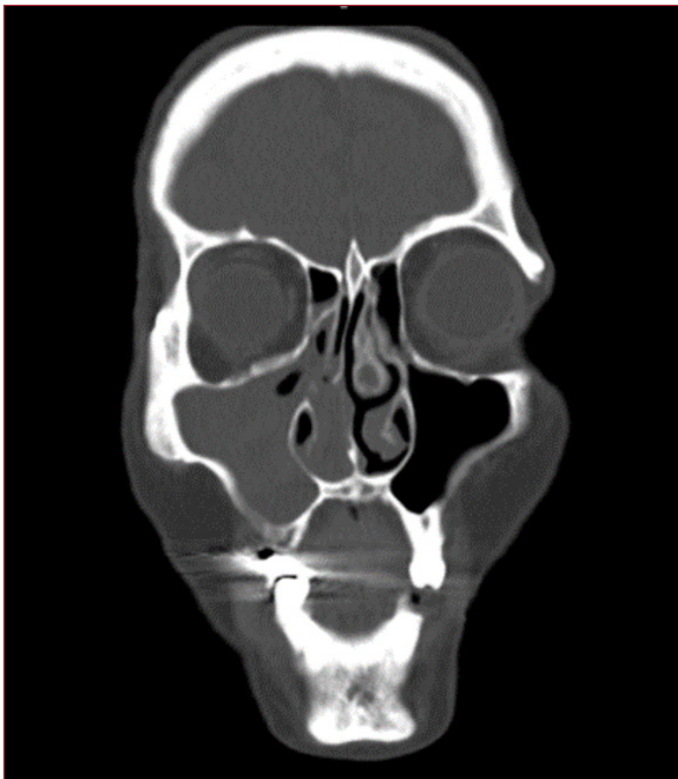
Coronal CT scan revealed opacification of the right maxillary sinus and a soft tissue density mass in the nasal cavity
